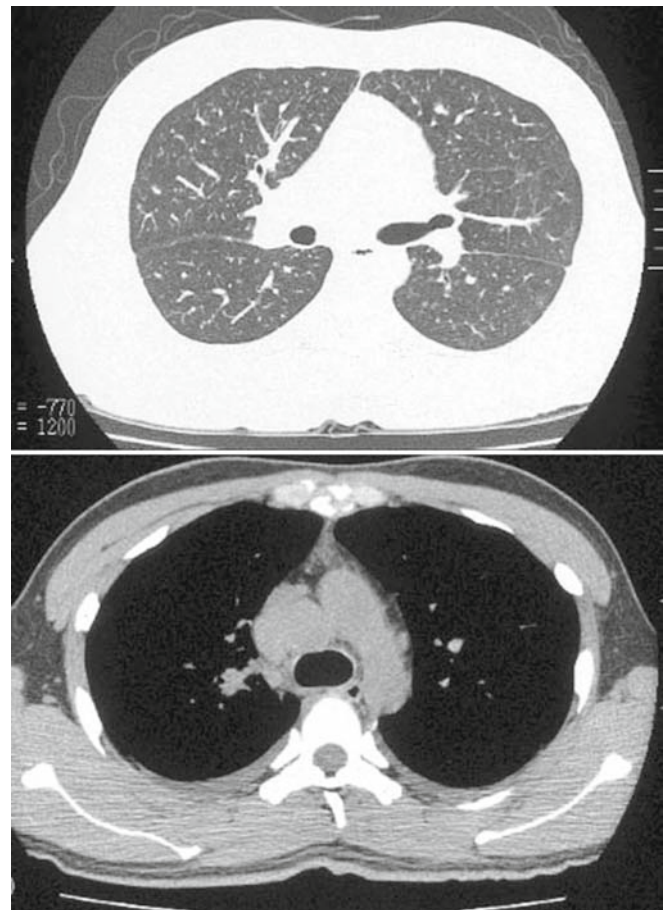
Chest high-resolution computed tomography (HRCT) revealed bronchovascular bundle thickening and mediastinal lymphadenopathy
